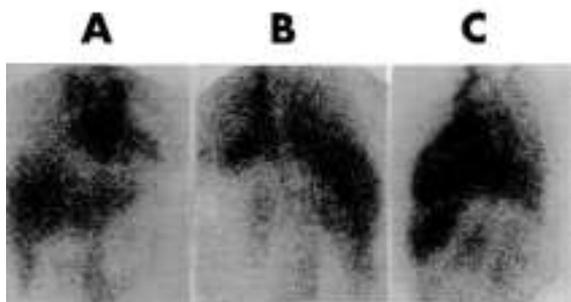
Case #1: ^{99m}Tc -labeled red cell scintigraphy showing absence of functioning splenic tissue in an anterior view (A), posterior view (B), left lateral view (C).
